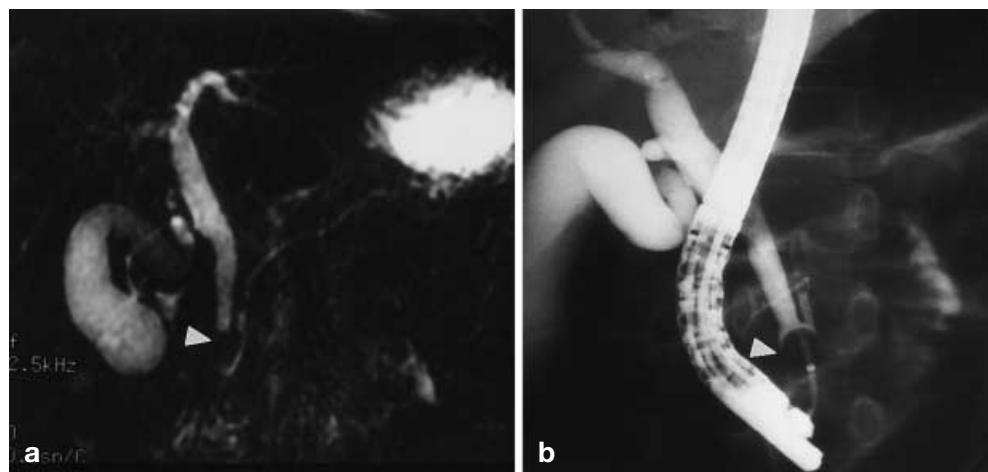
Five-year-old boy who presented with abdominal pain and vomiting. An outside ultrasound demonstrated biliary tract obstruction without a cause. MRC (a) shows a filling defect in the distal common bile duct (arrowhead). ERCP (b) confirmed the suspected CBD stone (arrowhead), which was removed endoscopically
